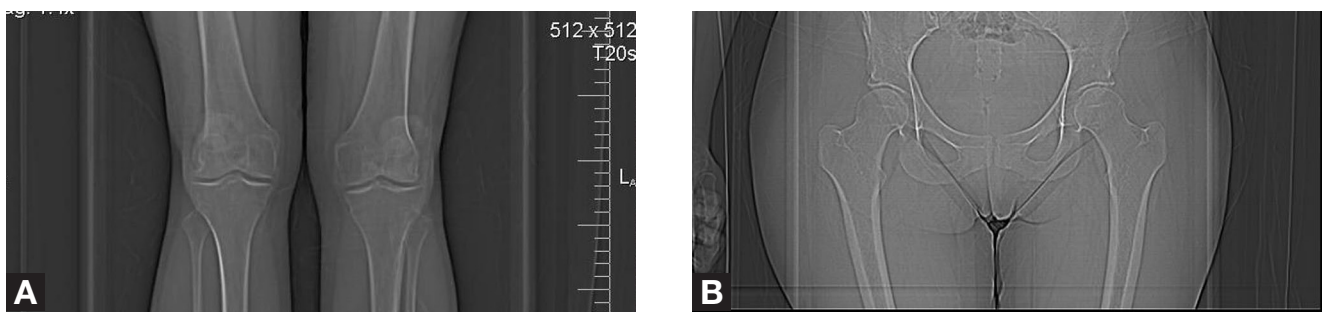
Anteroposterior radiographs of bilateral knees (A) and hips (B).
